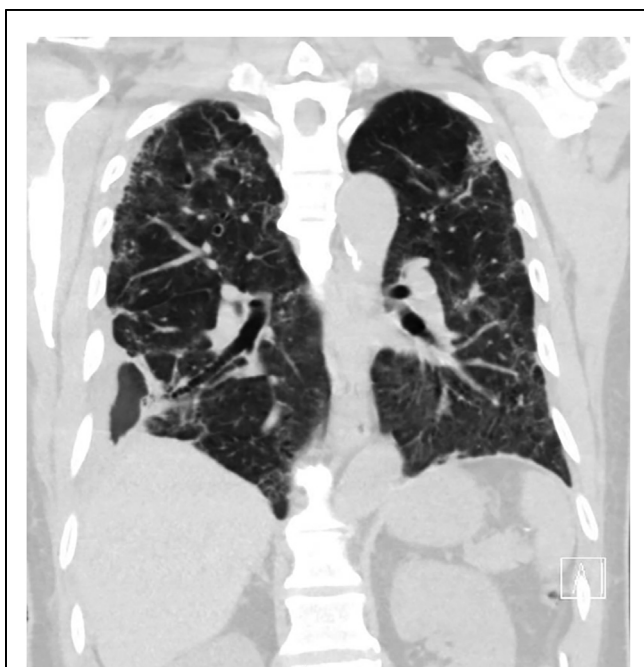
Computed tomographic image of bronchopleural fistula tract.
